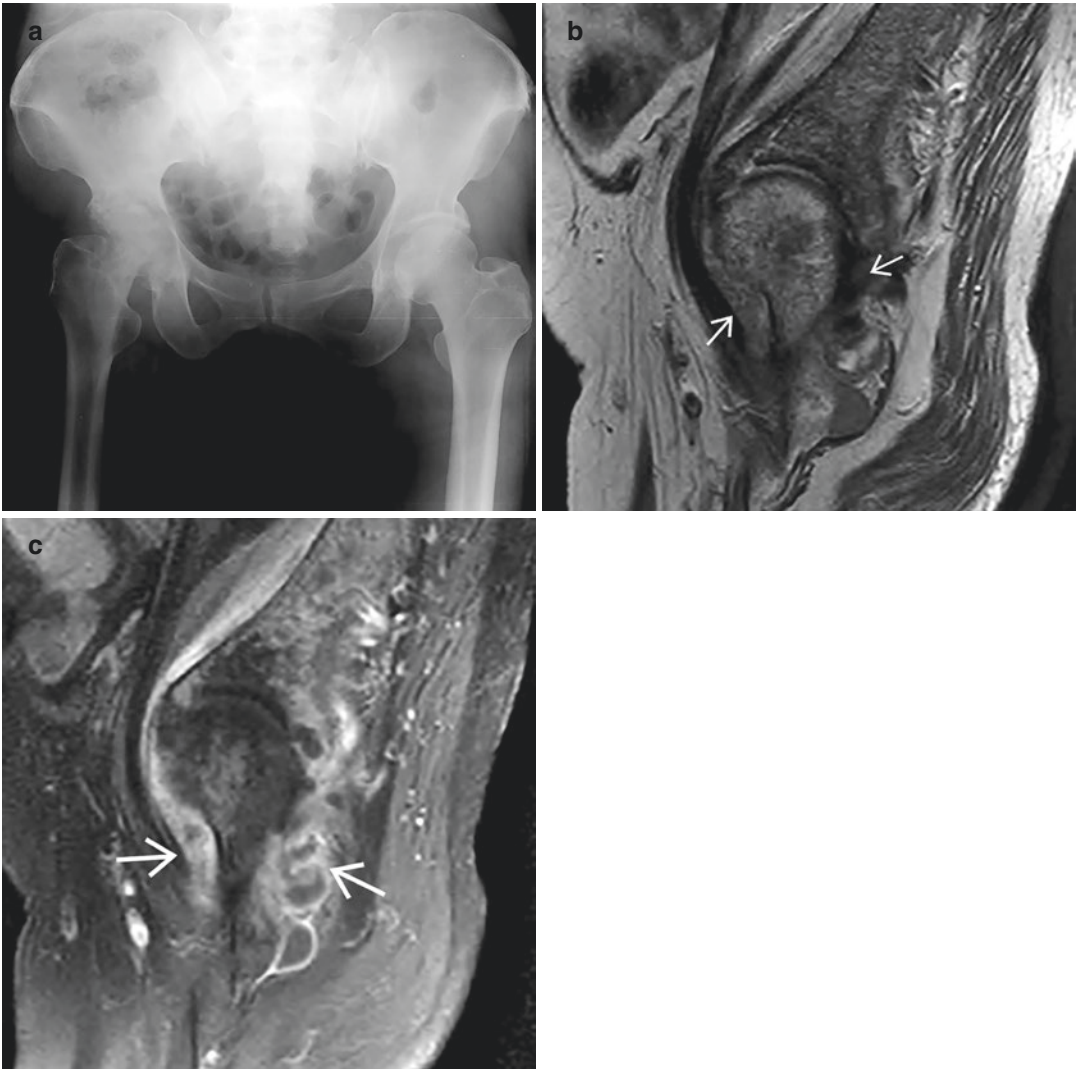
Tuberculous arthritis in a 74-year-old woman who had a right hip pain for 2 weeks. (a) Frontal radiograph shows destruction of the right hip joint with medial wall deformity of the acetabulum (protrusio acetabuli).
